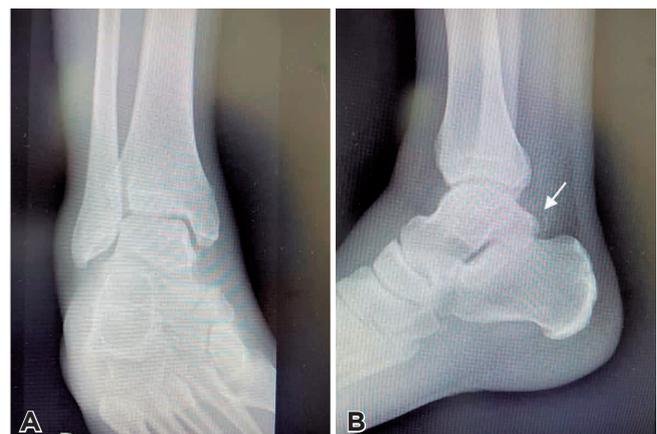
Preoperative A) anteroposterior and B) lateral radiographs of the right ankle, showing suspicious findings on the posteromedial aspect of the talus (arrow).
